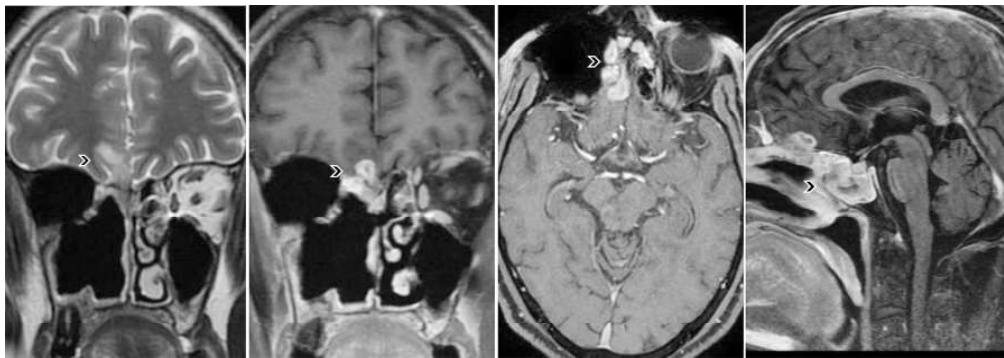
MRI brain T2W coronal, T1W coronal, axial and sagittal contrast sequences of a patient showing subdural empyema collection in the right basi-frontal region under the gyrus rectus
